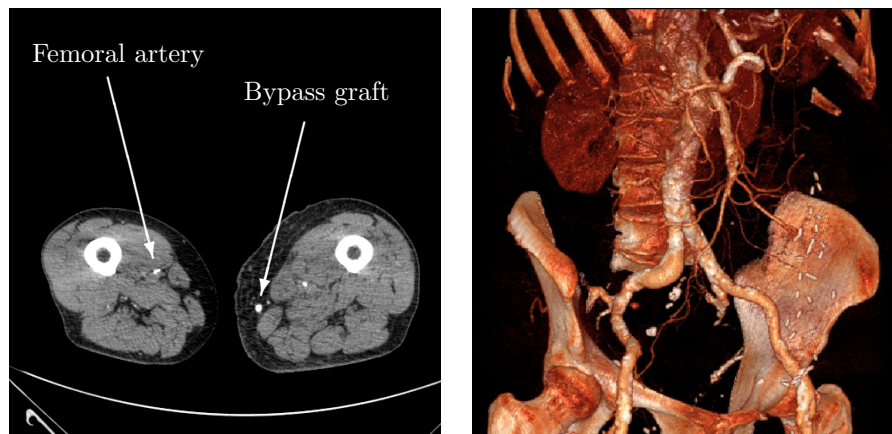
Images obtained with CT Scan. Left: 2D image of the legs of a patient. Note the femoral artery on the healthy left leg and the bypass graft (in-situ vein) on the right leg. Right: 3D reconstruction from the abdominal aorta to the left and right iliac arteries (realised with the software DirectView-V5CR[®], Kodak Carestream).
